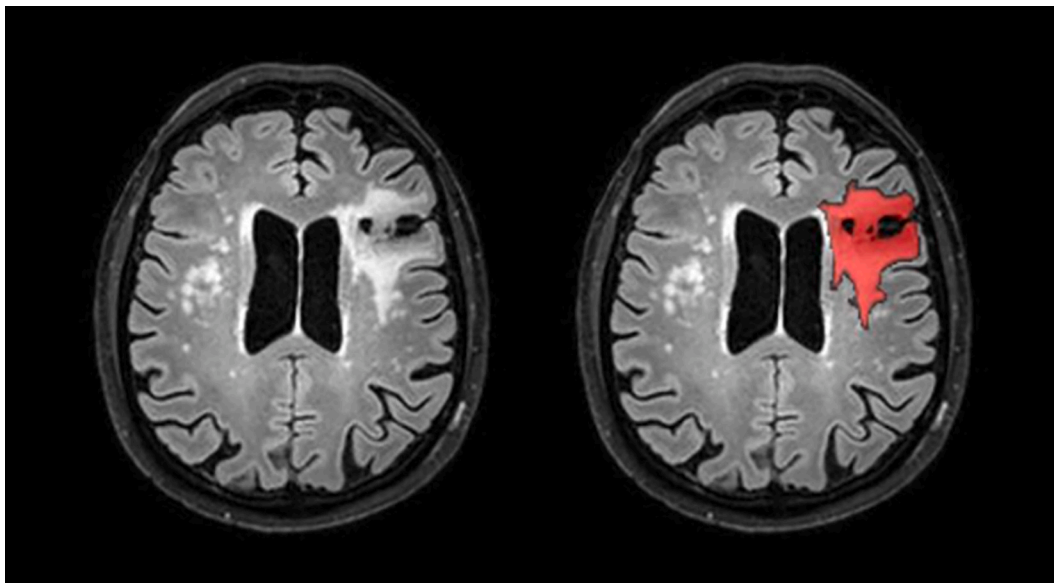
Example of a FLAIR image with a manual segmentation of a large cortical brain infarct (left: original image; right: manual segmentation in red). (For interpretation of the references to colour in this figure legend, the reader is referred to the web version of this article.)
